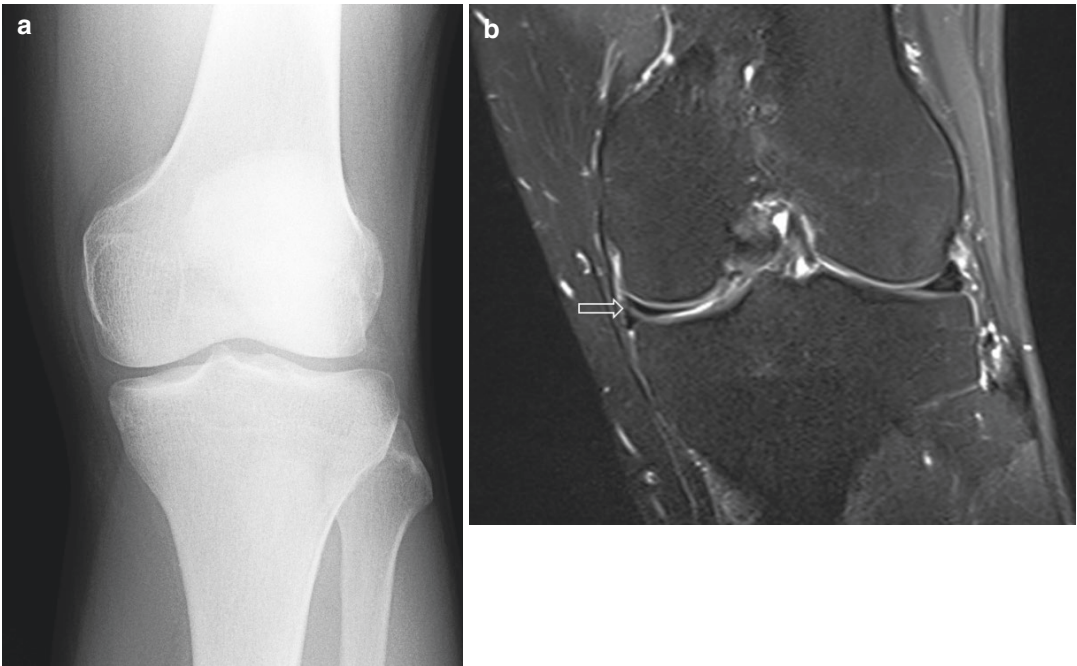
A 37-year-old man who presented with left knee pain. (a) Frontal radiograph of the left knee shows no significant abnormality. (b) Coronal fat-suppressed PD-W MR image of the left knee shows a horizontal tear of the medial meniscus involving its inferior surface, evident as
